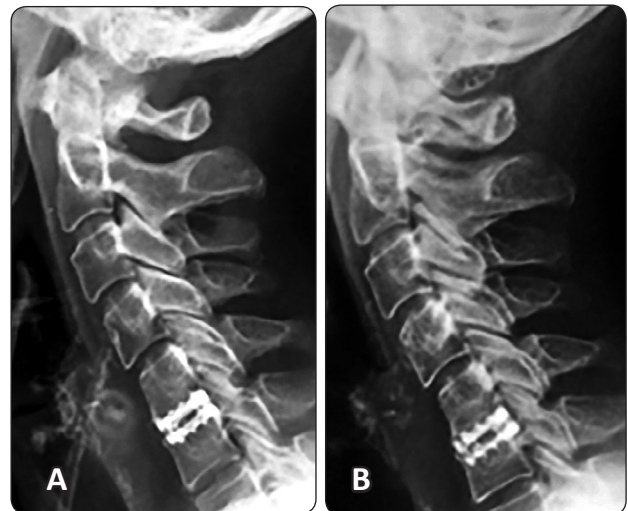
(A) Postoperative and (B) End follow up (12 months) lateral X-ray of the cervical spine after ACDF C5-C6 showing inferior cage subsidence.
